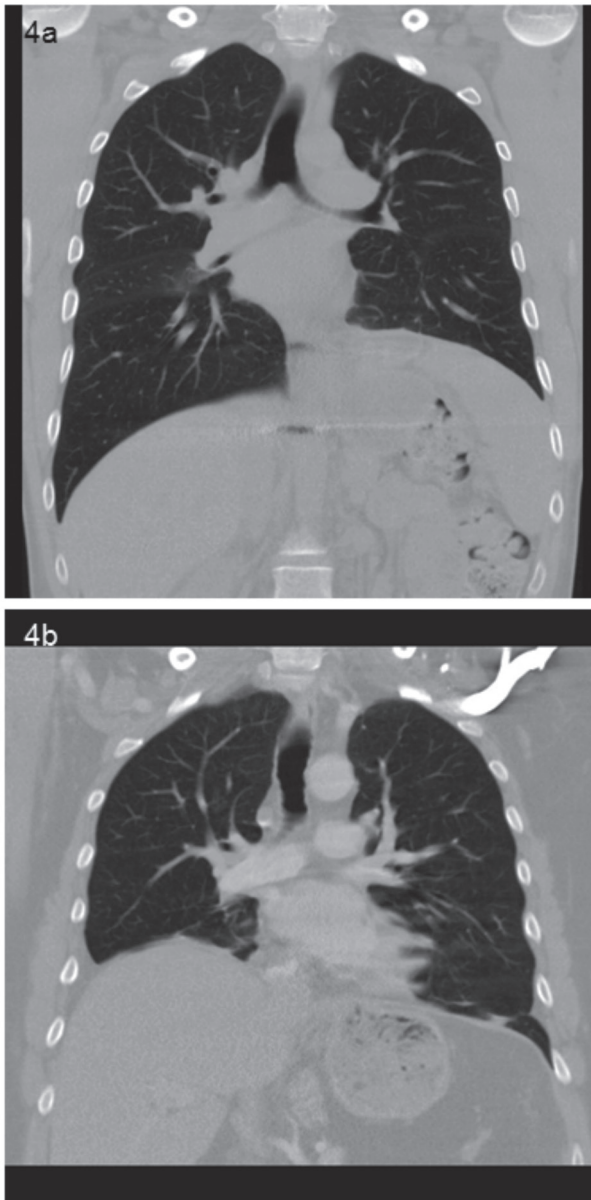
(a) Postoperative coronal CT-scan of the chest of patient 1 showing no signs of recurrence. (b) Postoperative coronal CT-scan of the chest of patient 3 showing no recurrent hernia.
